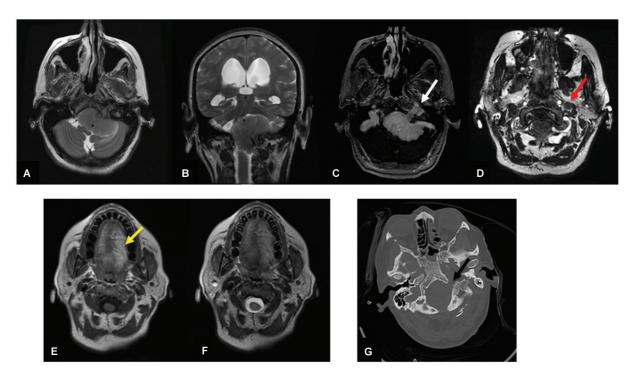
A 50-year-old female with skull base meningioma with perineural spread. Findings: T2 axial and coronal (A and B), post-contrast T1 fat-saturated axial (C), and FIESTA axial sections (D) showing (A) broad-based extra-axial homogeneous left petroclival tumor with mass effect on adjacent structures. (B) Extension of the tumor into the spinal canal through the foramen magnum (C) homogenously enhancing tumor with thickening and enhancement of the left hypoglossal nerve with perineural enhancement (white arrow). (D) Thickened left hypoglossal nerve in the parapharyngeal space (red arrow). (E and F) T1 and T2 axial images demonstrating fatty atrophy and degeneration of the left half of the tongue (yellow arrow). (G) Axial bone window computed tomography section demonstrating erosion and enlargement of left hypoglossal canal (black arrow).
